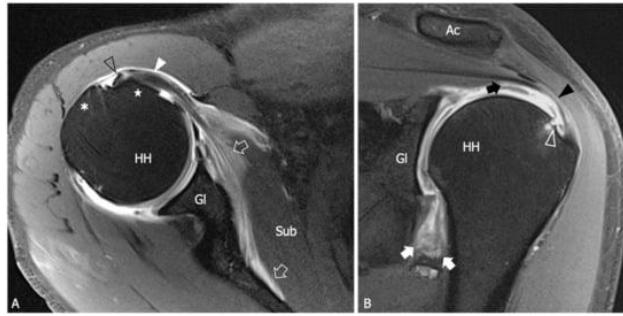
Adhesive Capsulitis in a 45-year-old Man with Severe Limitation of the Glenohumeral ROM after a Trauma who was Submitted for an MRA for a Suspected Labral Tear. (A) Axial and (B) Coronal tSE fat-suppressed T1-weighted MR images obtained after intraarticular injection of gadolinium demonstrate anterior extravasation of the contrast medium (outlined arrows) into and underneath the subscapularis muscle (Sub) as a consequence of capsular stiffness and fissuration. Note the abnormally low distension of the axillary recess (arrows) and its markedly thickened walls. In (B) a partial thickness tear (white outlined arrowhead) of the articular side of the supraspinatus tendon (black arrowhead) is also evident. In effect, the tear involves both the inner fibers of the supraspinatus and the joint capsule, which are merged at this level to form the superior complex. As a consequence, note the superior migration of the contrast outside the joint cavity (black arrow). Black outlined arrowhead, long head of the bicep tendon; white arrowhead, subscapularis tendon; asterisk greater tuberosity; star, lesser tuberosity; HH, humeral head; GI, glenoid; Ac, acromion.¹⁵
